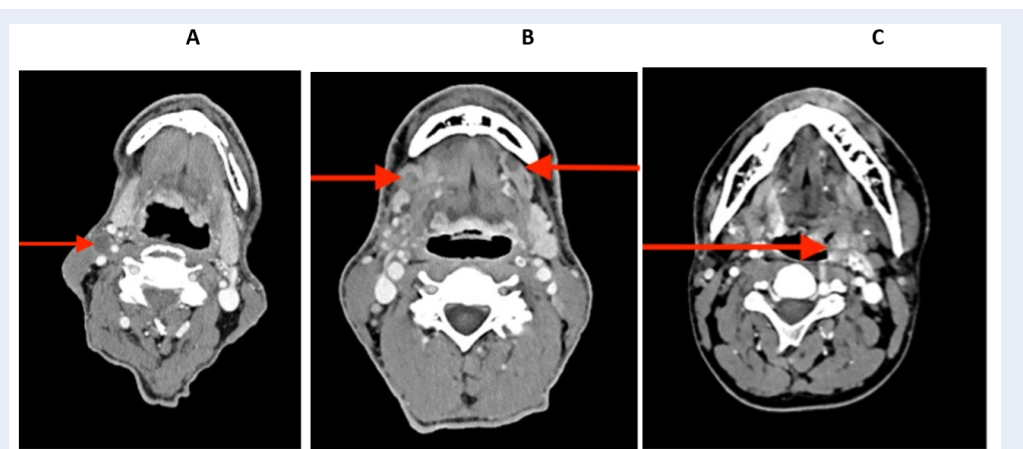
Pre-operative contrast-enhanced CT images of three patients. A. Patient №37 - 49-year-old male diagnosed with locally advanced (T3N1M0) stage of laryngeal squamous cell non-keratinizing cancer. B. Patient №17 - 66-year-old female diagnosed with locally advanced (T3N1M0) stage squamous cell non-keratinizing cancer of mouth floor. C. Patient №41 - 72-year-old male diagnosed with locally advanced (T4aN0M0) stage laryngeal squamous cell keratinizing cancer.
